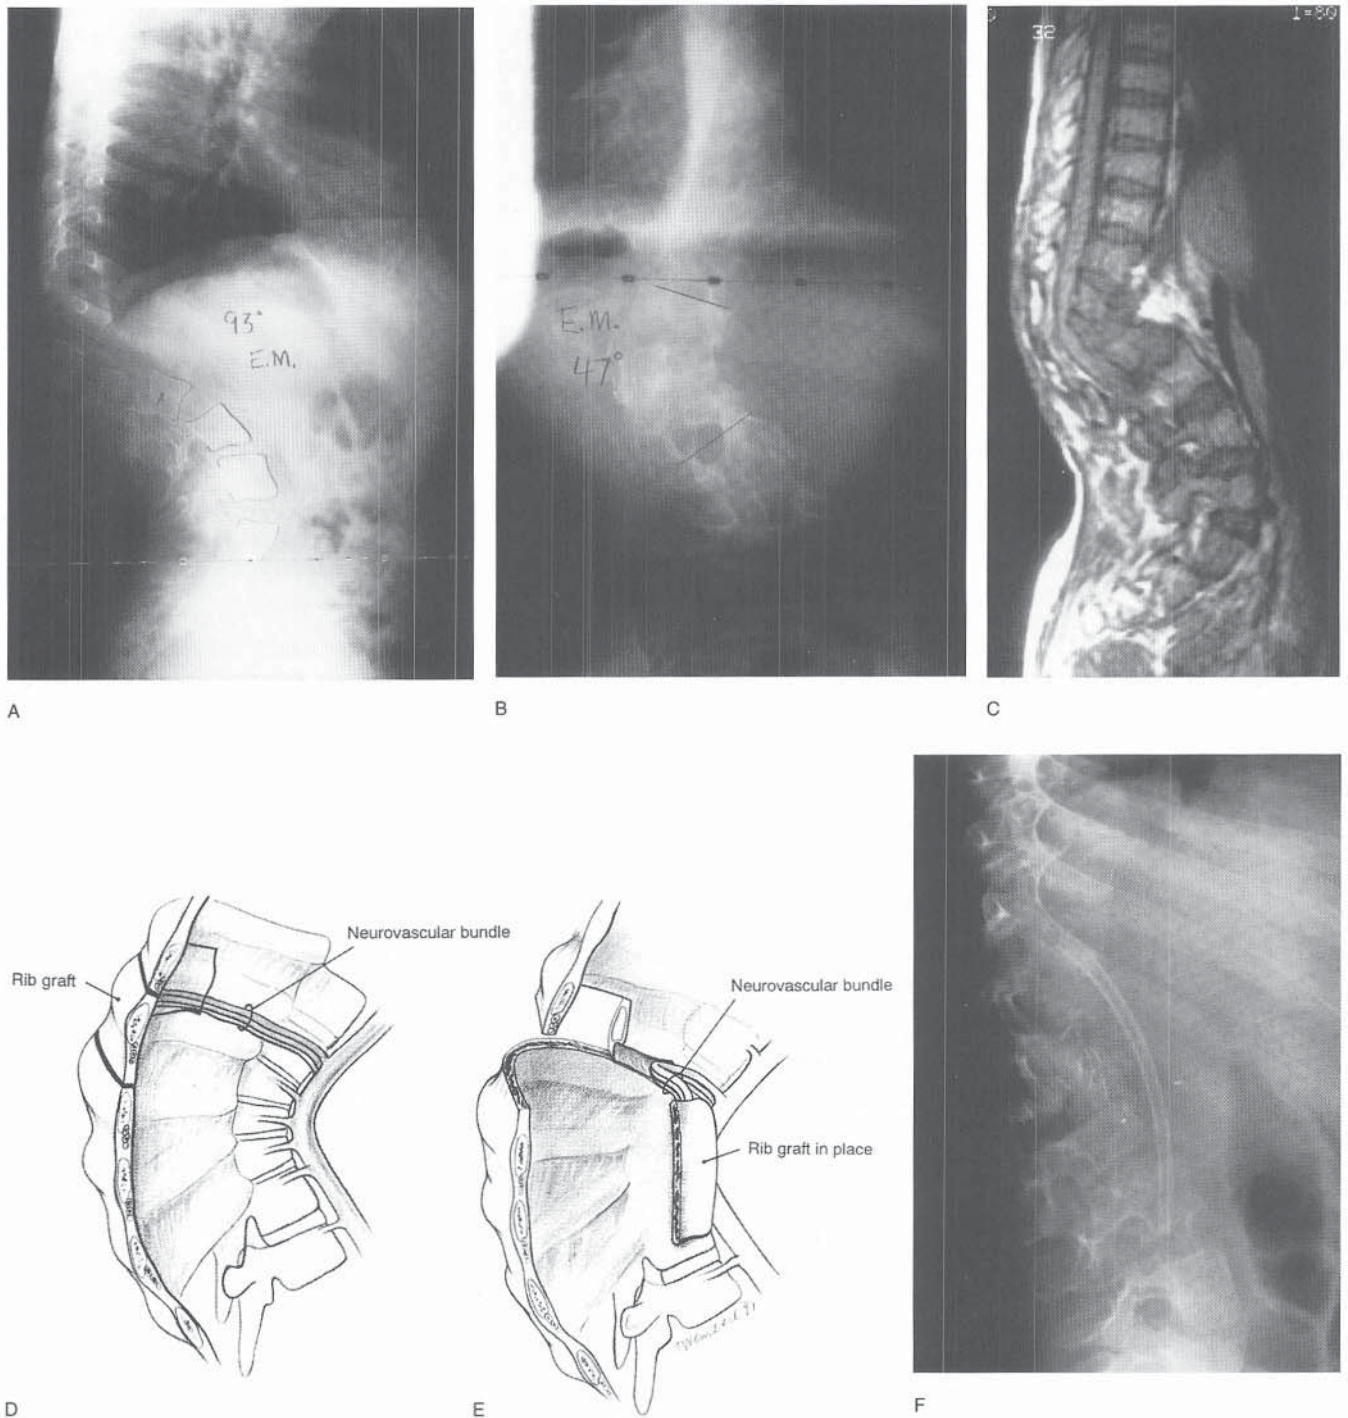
A and B, Radiographic appearance in a 10-year-old boy with spondyloepiphyseal dysplasia and an abrupt 93-degree kyphosis at L1 (and 47-degree scoliosis) due to a small posterolateral quadrant vertebra. He had previously undergone an attempt at anterior and posterior fusion with posterior instrumentation; that intervention was complicated by infection. The hardware was removed and the deformity worsened. He remained neurologically normal. C, MRI demonstrated the abrupt kyphosis and its effect on the spinal cord. D and E, A vascularized rib strut graft was used during the repeat anterior and posterior fusion. The neurovascular bundle was isolated from the rib near its origin to allow the rib to be cut. The rib selected for a graft usually corresponds to the upper vertebral level requiring fusion (D). When the rib is seated into the vertebral bodies, the vascular bundle must be free of tension. The ends of the ribs should be exposed subperiosteally for a length of 1 cm to allow secure fixation into the vertebral bodies (E). (D and E from Herring JA: Anterior spinal surgery. In Weinstein SL (ed): *The Pediatric Spine: Principles and Practice*, p 1419. New York, Raven Press, 1994. Copyright © 1994 by Lippincott, Williams & Wilkins.) F, The vascularized rib was fixed in the T10 and L3.
